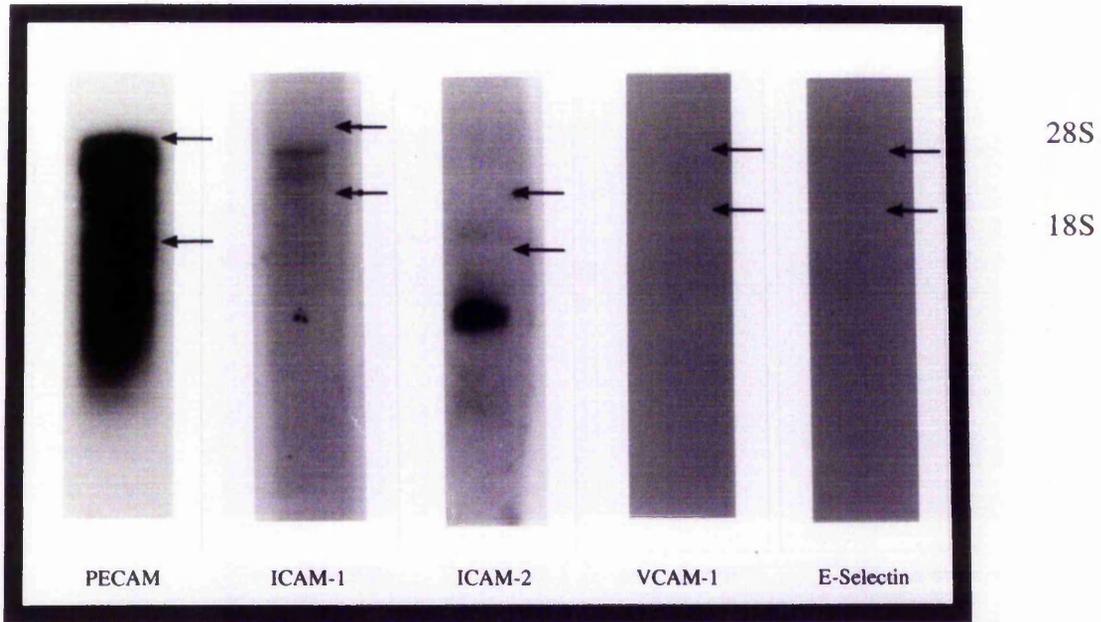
Northern analysis of cell adhesion molecule expression in placentae. RNA was extracted from the placentae, run on agarose gels and blotted onto nylon membranes. The membranes were then hybridised with a cDNA probe as described in sections 2.2.13 - 2.2.19, washed to a final stringency of 0.5 x SSC at 65°C. Autoradiography was performed with Fuji x-ray film overnight at -70°C. The 28S and 18S rRNA bands are marked by the arrows.
